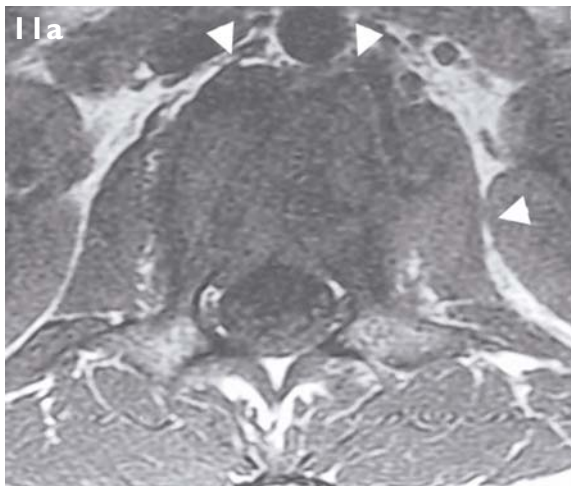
MR imaging of TB spondylitis with subligamentous and left psoas involvement. a) Axial T1-W MR image taken through L1 vertebral body shows inflammatory tissue in the subligamentous region and to the left of vertebral body (arrowheads). b) Enhanced fat-suppressed axial T1-W MR image taken through L1 vertebral body shows marked enhancement of the inflammatory tissue in the subligamentous region and in the left psoas muscle (arrowheads). Enhancement within the vertebral body is also noted (arrow). c) Enhanced fat-suppressed coronal T1-W image shows enhancement of the L1 and L2 vertebral bodies (small arrows). Enhancement of the left psoas muscle is also noted (large arrow).
